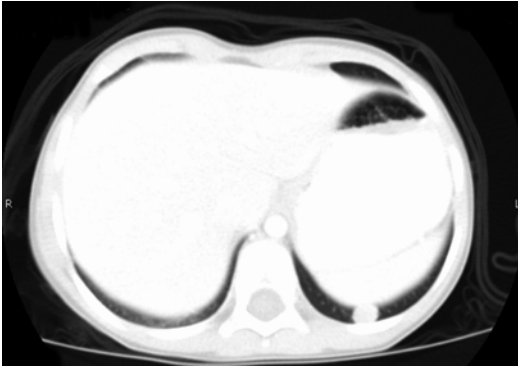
Computed tomography scan showing peripheral lung lesions
